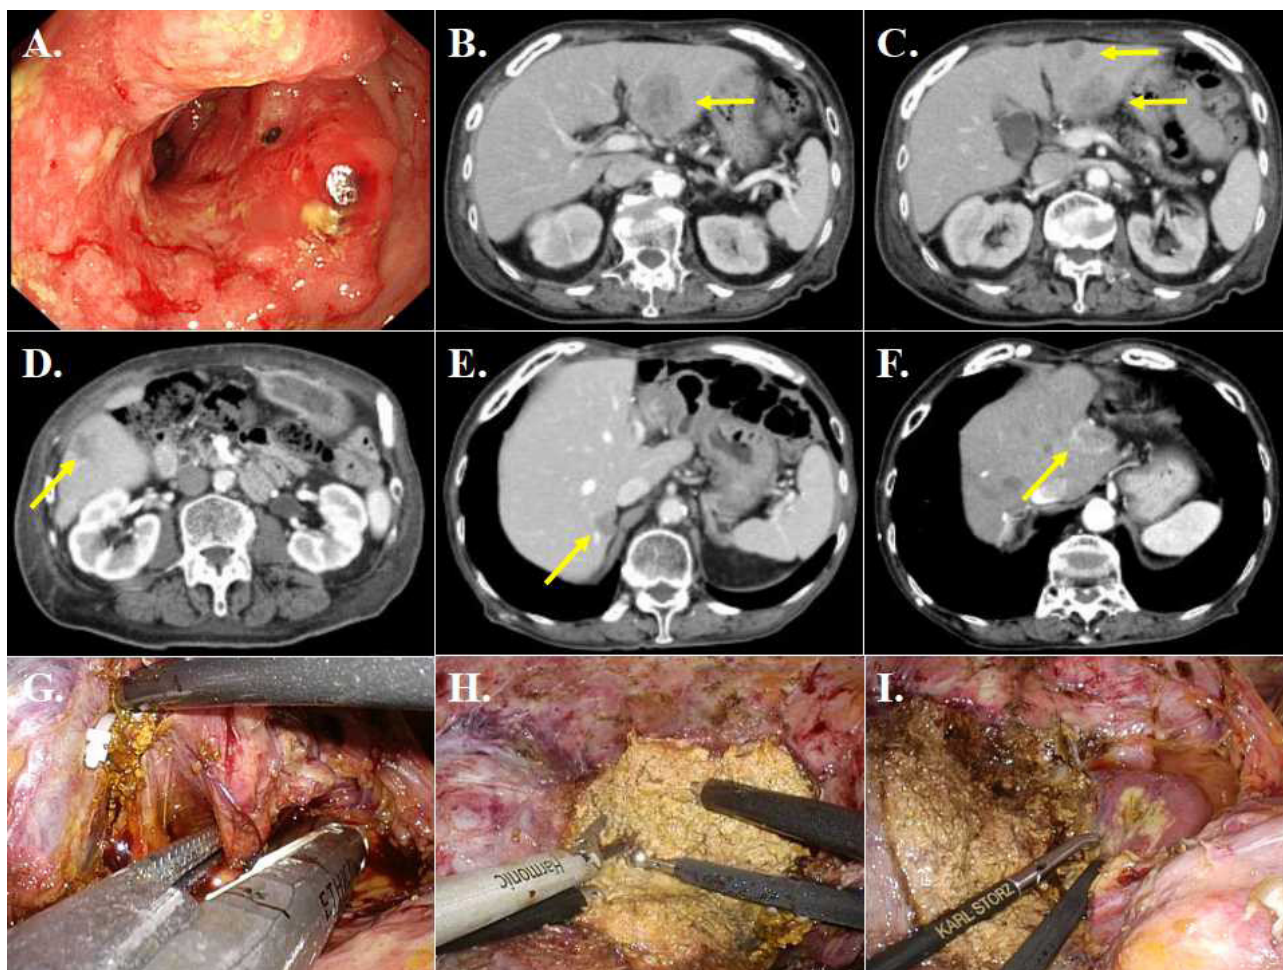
(A-C) Colonoscopy and enhanced CT scan of the abdomen demonstrated advanced transverse colon cancer and concomitant multiple liver metastases, all of which was resected after multidrug chemotherapy (S2, S3 yellow arrows, S5 and S8 lesions were not shown). (D) Subsequently, solitary S5 liver metastasis was detected and secondary resection (S5 subsectionectomy) was performed. (E) Third liver resection for two lesions (S7 and S8) were performed. (F) The new S4 lesion close to the cut margin was again detected. (G-I) Even after the history of multiple resection of bilobar legions, she also underwent successful laparoscopic medial sectionectomy under perioperative continuation of aspirin monotherapy (G: severing the left glissonean pedicle, H: liver parenchymal transection using two surgeon technique, I: After the resection of medial section).
